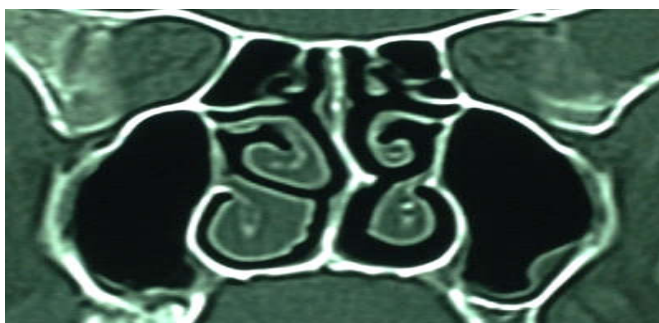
Figure (C): CT scan of paranasal sinuses (coronal section) showing posterior measurements which are taken in the last image where the inferior turbinate bone can be identified
